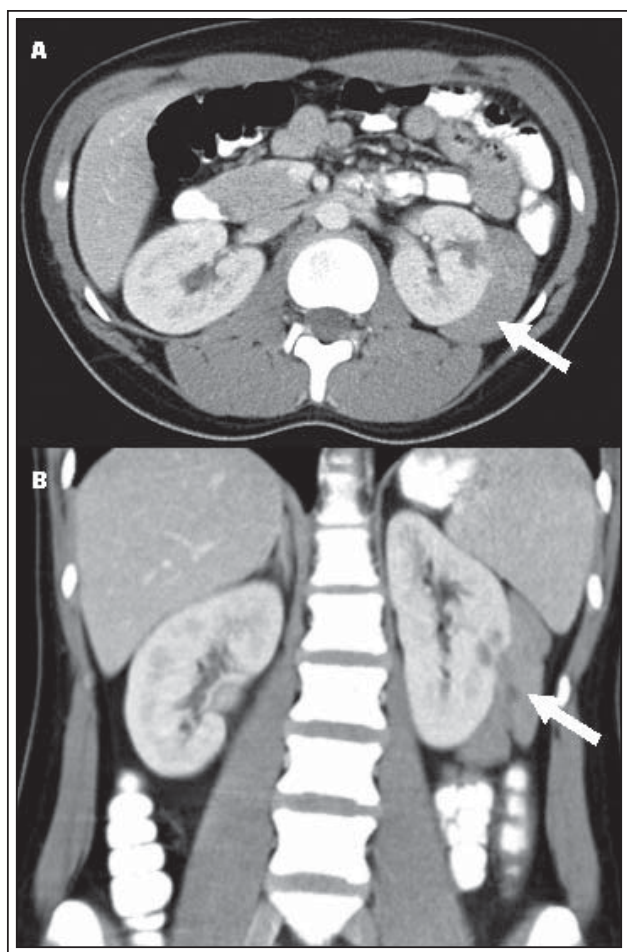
Axial (A) and coronal (B) cuts of a computed tomography scan, demonstrating a large enhancing mass (arrows) arising from the left kidney (R.E.N.A.L. Nephrometry Score = $3+1+3+x+3=10x$).
